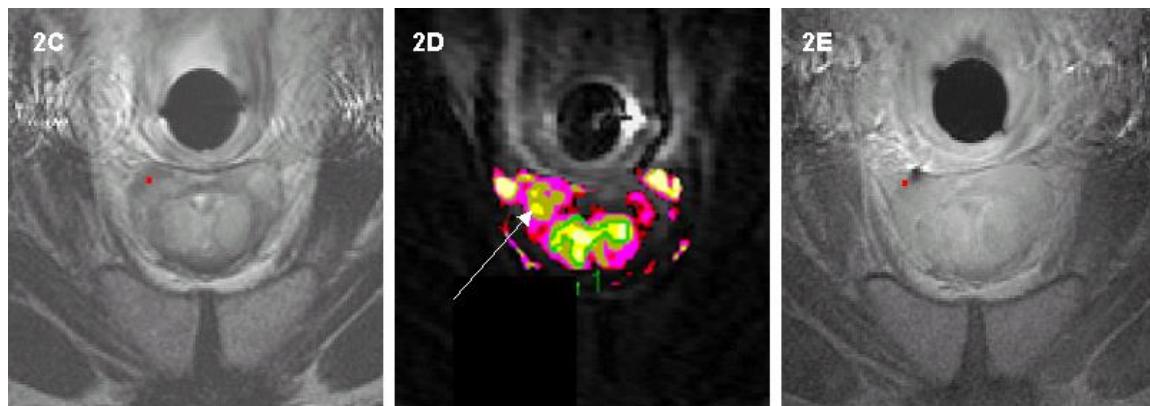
A case example whereby T2W FSE images (2C) shows a suspicious lesions in the peripheral zone which was targeted for biopsy (red dot). Dynamic contrast MRI color-coded for contrast kinetics (2D) shows normal activity in the central gland and neurovascular bundles, and activity suspicious of malignancy in the peripheral zone (arrow) corresponding to the targeted site. The biopsy needle can be visualized on axial images (2E - signal void) prior to tissue acquisition in close proximity to the intended target (red dot).
